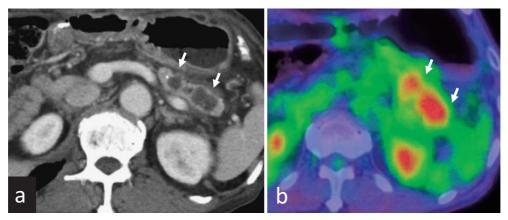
(a) Enhanced CT showing two hypovascular tumors in the remnant pancreas (arrows). (b) Positron emission tomography showing abnormal accumulation of 18F-fluorodeoxyglucose in the remnant pancreas (SUV max, 5.4).
